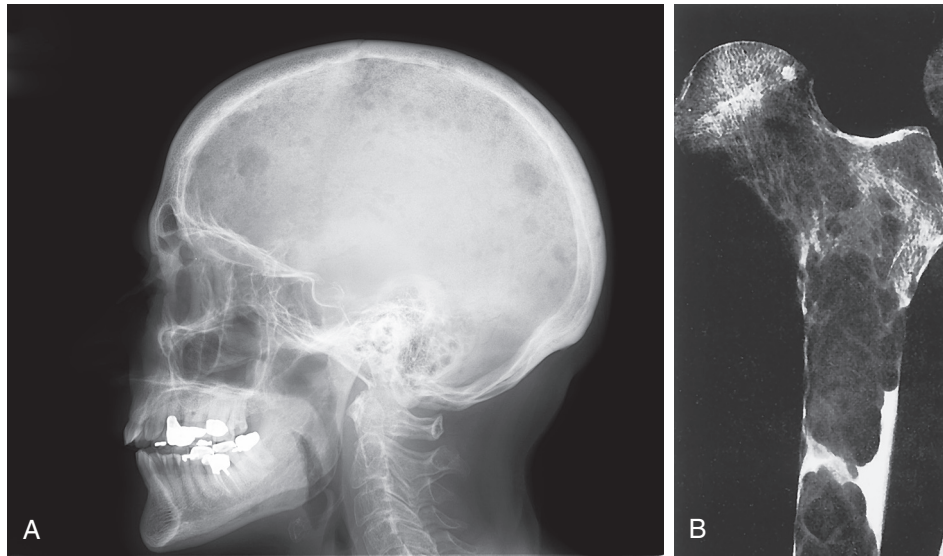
Osteolytic Lesions in Individuals with Multiple Myeloma. A, Lesions in the skull on radiograph in a client with myeloma. B, Roentgenogram of femur showing extensive bone destruction caused by tumor. Note absence of reactive bone formation. (A from Abeloff M et al: *Abeloff's clinical oncology*, ed 4, Philadelphia, 2008, Churchill Livingstone. B from Kissane JM, editor: *Anderson's pathology*, ed 9, St Louis, 1990, Mosby.)
